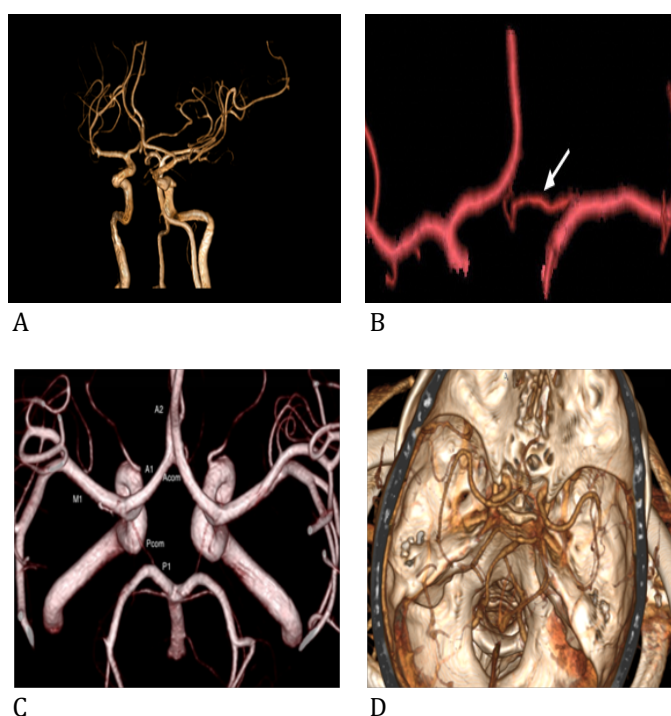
A: 3-D image showing classical Circle of Willis (Type A anterior circulation). B: VRT image showing hypoplastic left A1 segment of ACA (Type H anterior circulation). C: 3-D labelled CTA: Bilateral hypoplastic PCA (Type E posterior circulation). D: MDCTA showing Type E posterior circulation variant
